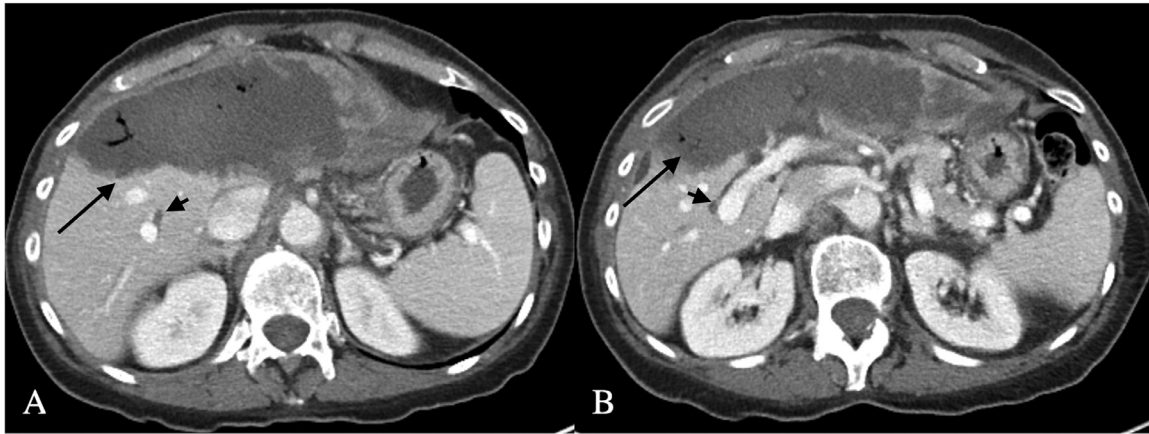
(A and B) 1 week after MWA, 2 axial views of contrast CT of Abdomen and Pelvis at different level reveals the extensive hypodensity and hypoperfusion of the left hepatic lobe, including segment 4, compatible with hepatic infarction. Additionally, there was moderate intra-hepatic biliary ductal dilation in the right hepatic lobe.
